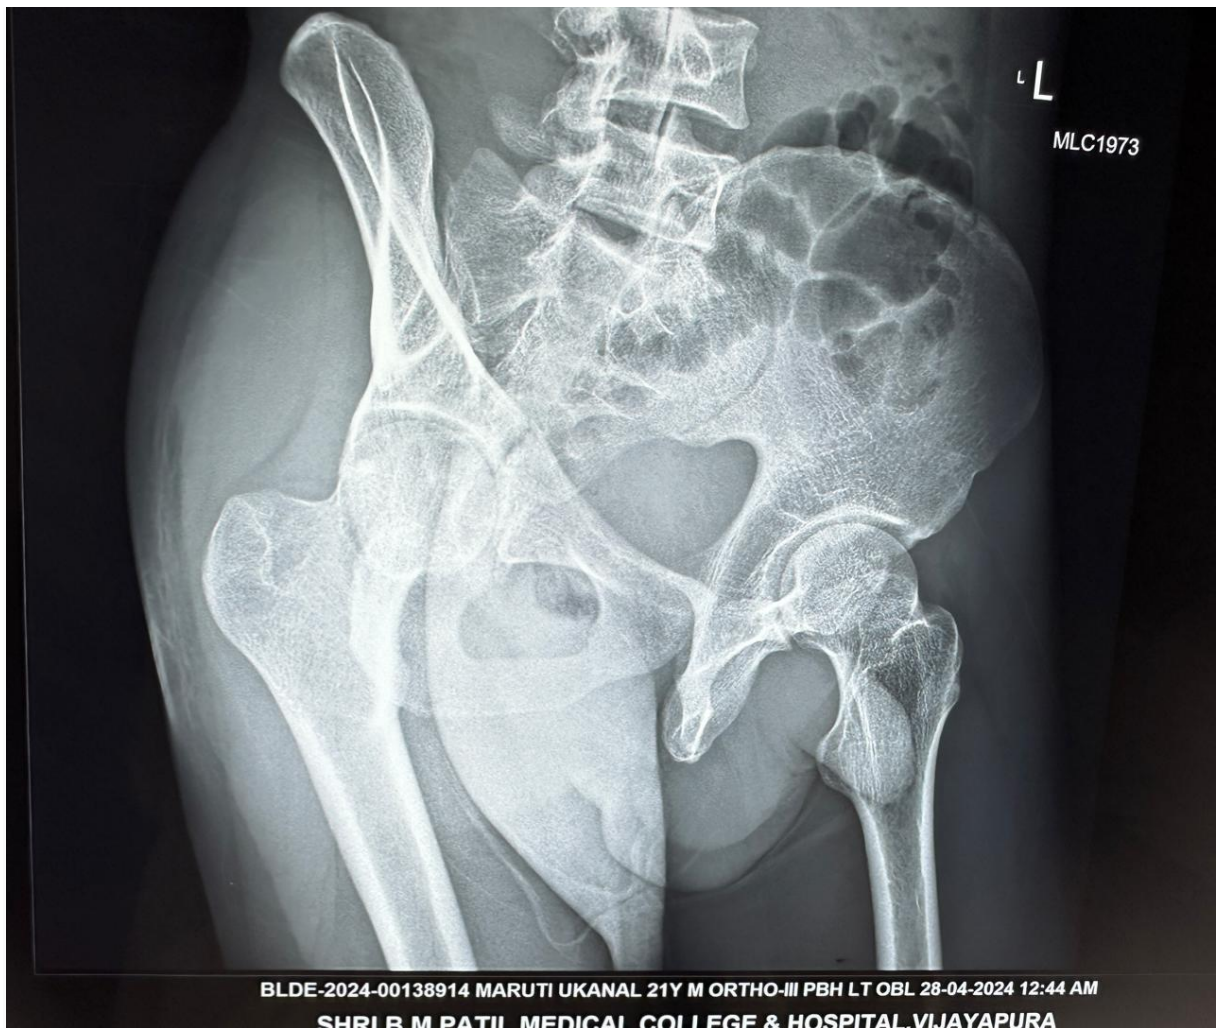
Right Obturator Oblique X-Ray view
